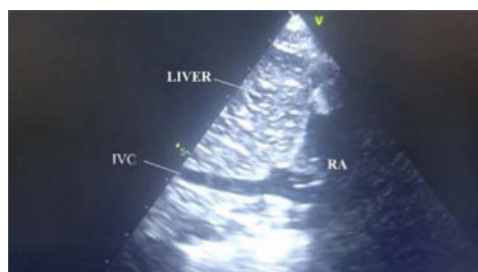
Ultrasound image of the subcostal view of the IVC in the focused cardiac ultrasound (FOCUS) examination. IVC, inferior vena cava; RA, right atrium.
